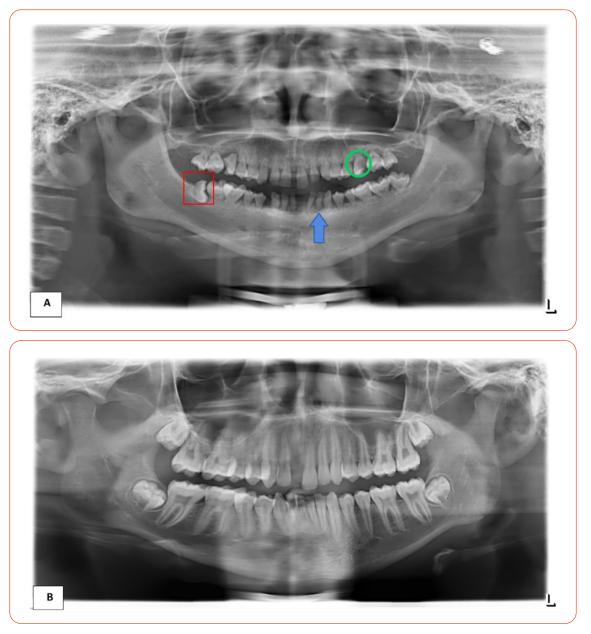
Figure A demonstrates a smaller maxilla and mandible compared to that of a normal 16-year-old in Figure B. Microdontia teeth with short roots of permanent dentition were noted with an example pointed out (blue arrow). There is horizontal impaction of the right lower third wisdom teeth (red box). The upper right molar demonstrates a carious lesion with periapical radiolucency (green circle).
